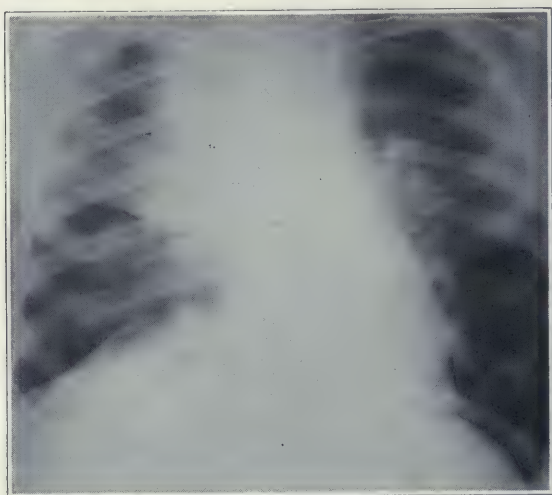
Hodgkin's disease with infiltration of the lung. There were enlarged nodes in the neck three months before this roentgenogram was taken, but the lungs were negative at that time.
